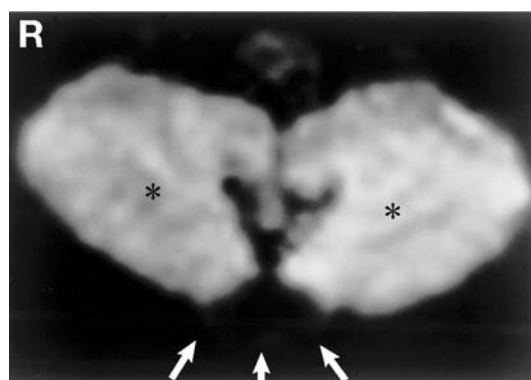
Magnified diffusion-weighted magnetic resonance image showing the lesion as a low signal intensity mass (arrows). Asterisk marks indicate the cerebellar hemisphere.
